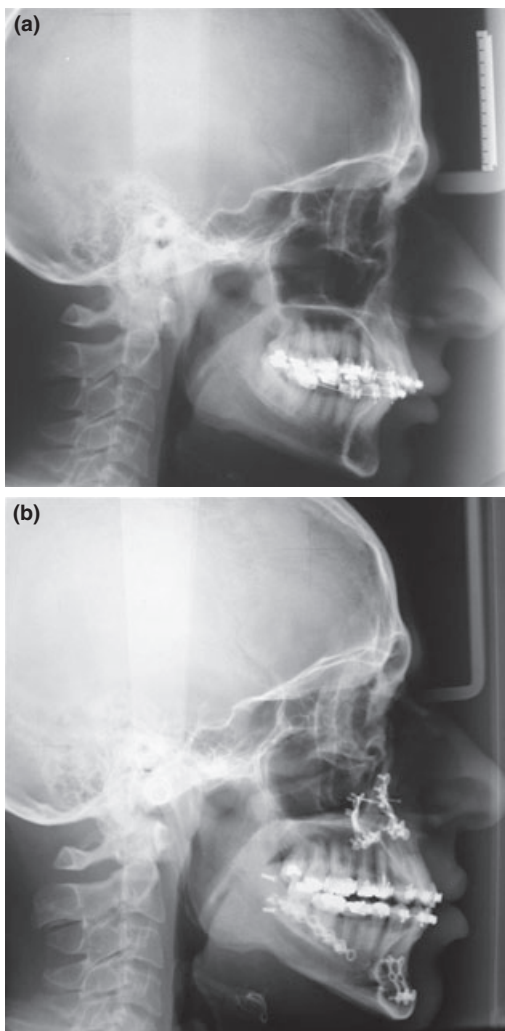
(a) Lateral X-ray image of the patient with the orthodontic appliance prior to the maxillo-facial surgery. (b) Lateral X-ray image of the patient after surgery (orthognathic surgery and mentoplasty).
